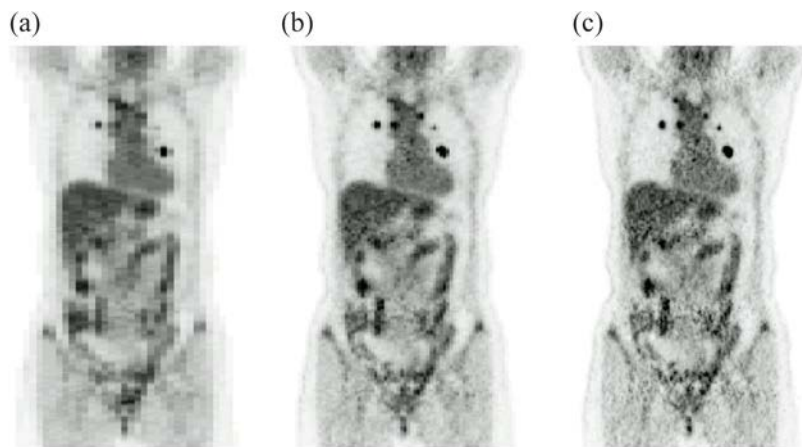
Coronal FDG-PET image reconstructed with a matrix size of 64 pixels (a), 128 pixels (b) and 256 pixels (c).
